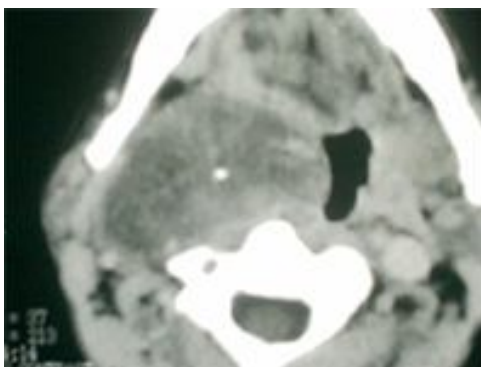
Axial CT scan of the same patient showing right poststyloid hypodense mass with homogenous enhancement and central calcific dot. The fat plane is preserved between the mass and the parotid. The mass encroaches on the the oropharyngeal airway.
